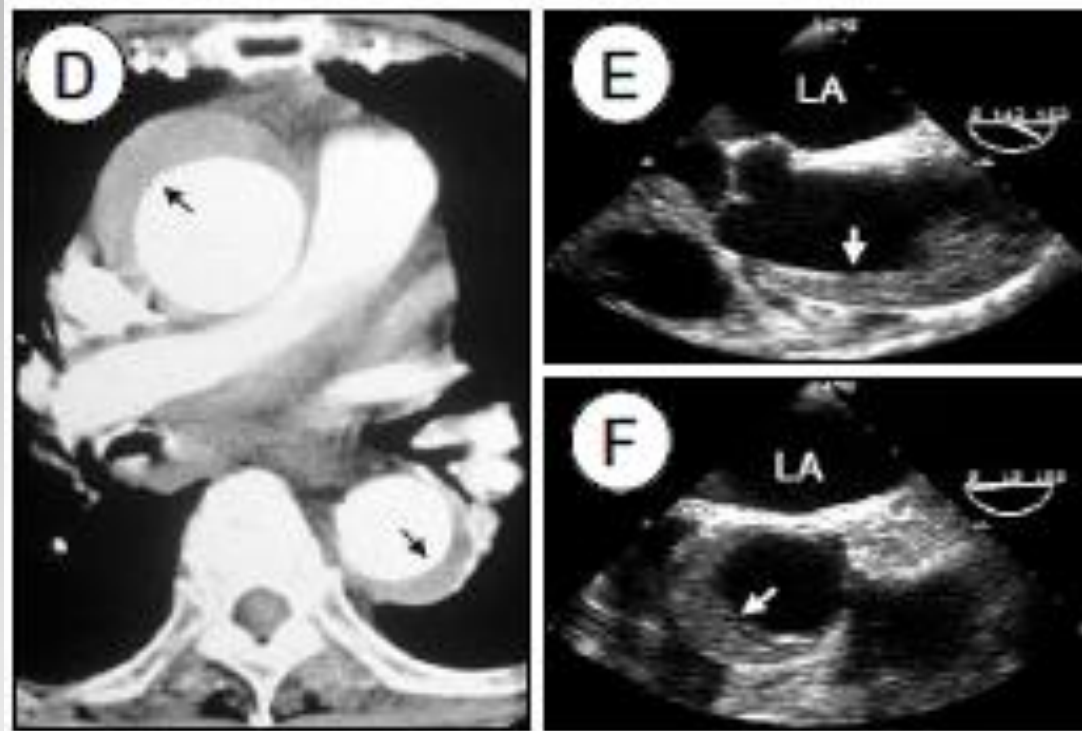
Transesophageal echocardiographic images showing various patterns of an 'echo-free space' or 'echo-lucent area' in patients with aortic intramural hematoma, which do not show any evidence of flow communication in color Doppler mapping or contrast echocardiography.
